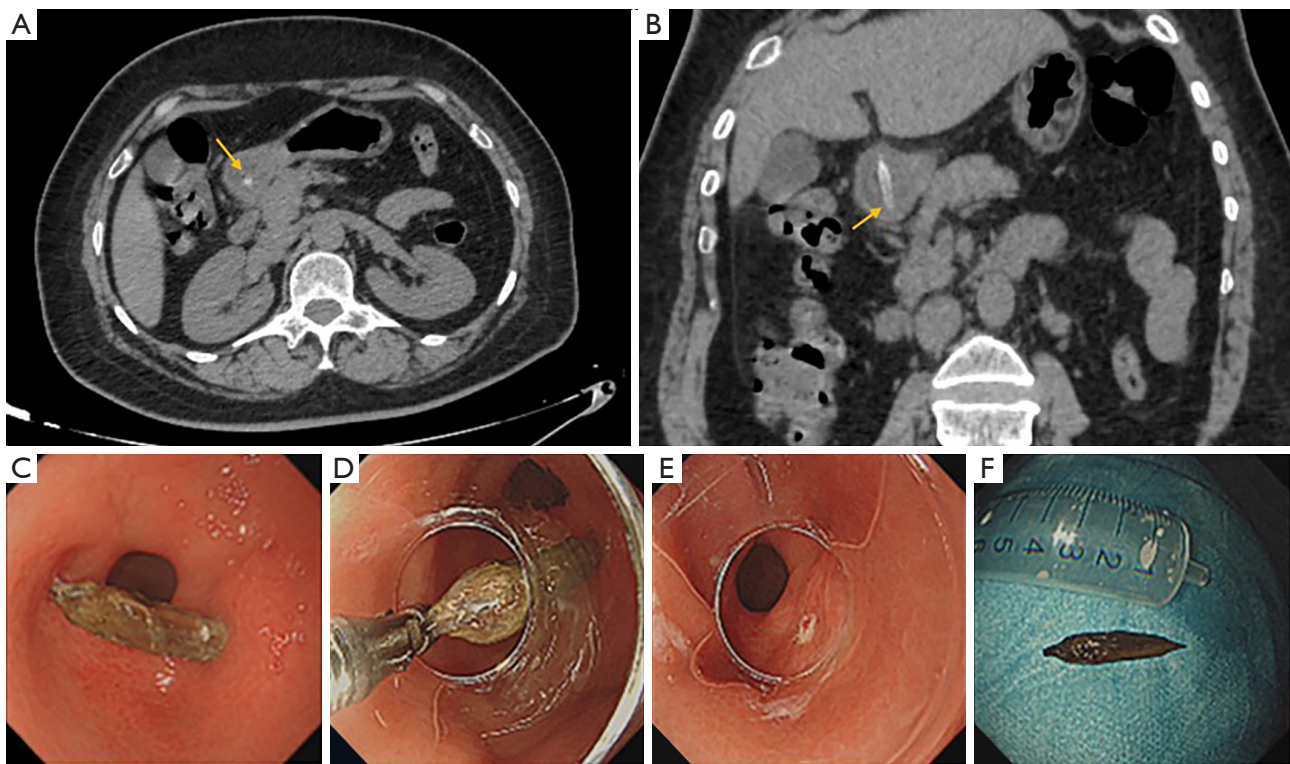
A jujube pit impacted in the gastric antrum. A 53-year-old woman presented with complaints of abdominal pain for seven hours without a history of jujube pit ingestion. CT suspected a jujube pit foreign body impacted in the gastric antrum with two sharp endpoints. Endoscopic findings were consistent with the CT findings, and the foreign body was removed. (A) Axial images demonstrate a dot high-density shadow (yellow arrow) in the gastric antrum, which can be easily missed. (B) MPR images clearly showed a jujube pit (yellow arrow) with both tips stuck under the mucosa. (C) Endoscopic visualization of a jujube pit in the gastric antrum. (D) Extraction of the jujube pit with foreign body forceps. (E) Small ulcerated foci are seen after jujube pit was removed. (F) Extracted jujube pit. MPR, multiplanar reconstructions; CT, computed tomography.
